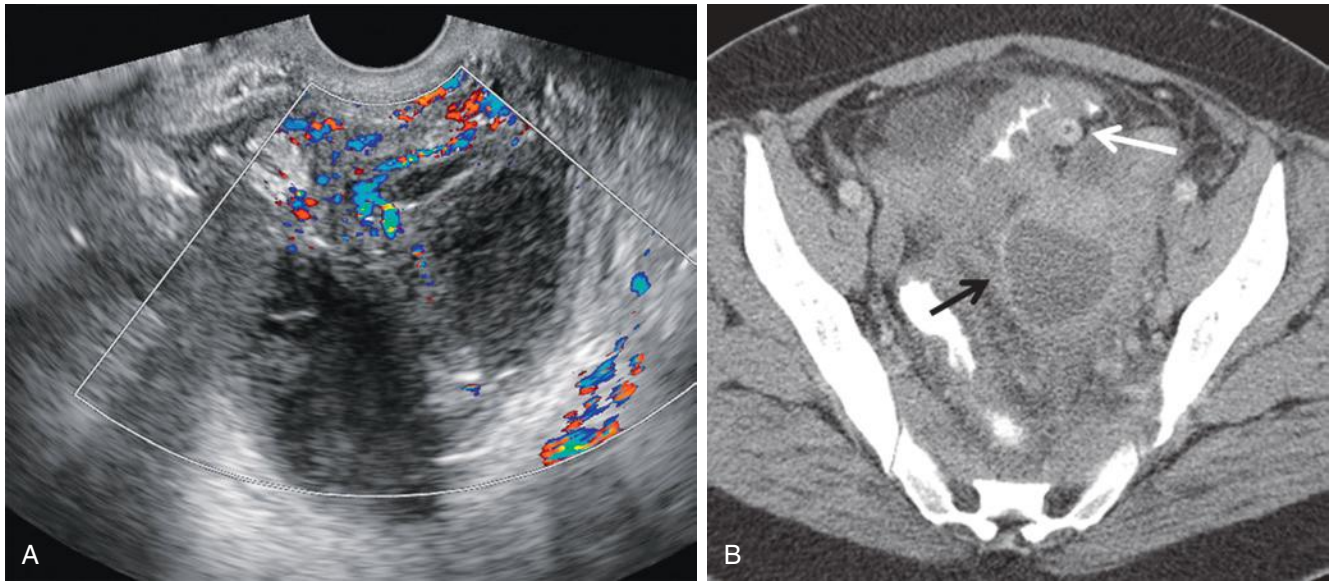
Tubo-ovarian abscess secondary to diverticulitis. A, Ultrasound image demonstrates a complex multiloculated pelvic mass with increased peripheral blood flow in a patient with left lower quadrant pain and fever. Note increased echogenicity in the surrounding pelvic fat consistent with inflammation. The patient had no risk factors for pelvic inflammatory disease. B, Computed tomography demonstrates the left pelvic abscess (*black arrow*). Note mural thickening of the adjacent sigmoid colon with numerous diverticula (*white arrow*) compatible with diverticulitis, which was the source of the abscess, confirmed at surgery.
